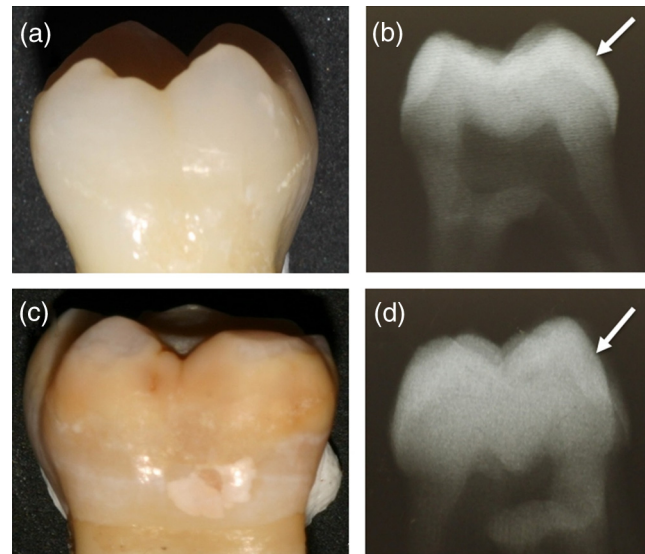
Clinical photographs and radiographic images of (a and b) a control tooth and (c and d) an MIH-affected tooth. The mesiodistal view of the tooth is presented in the clinical photograph (a–c), whereas it is the buccolingual view that is presented in the radiographic image (b–d) in an effort to observe the depth of penetration of the MIH lesion. The arrows point to the same area for both teeth, highlighting the area affected with MIH (d) and its corresponding healthy control area (b).
